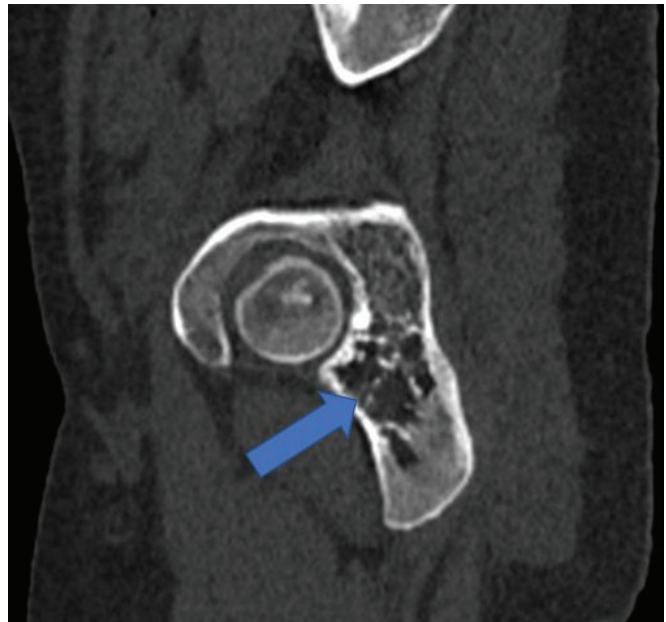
Sagittal reformatted CT image showing the lesion extending into the posterior column of the acetabulum (arrow).
